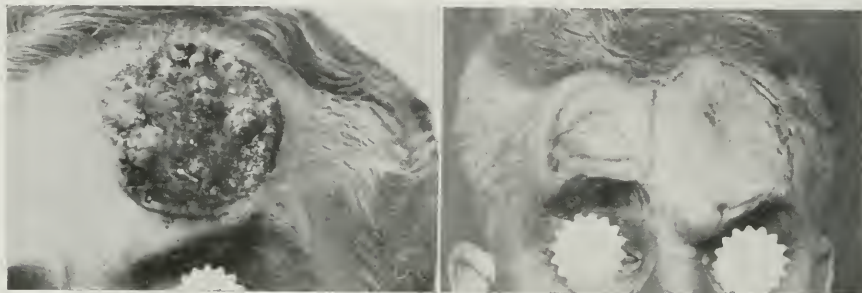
EPITHELIOMA OF THE FRONTAL REGION. IT HAD BEEN TREATED UNSUCCESSFULLY BY MANY METHODS, INVOLVING THE OUTER TABLE OF THE SKULL. DESTROYED BY ELECTRO-COAGULATION, TREATED BY DEEP ROENTGENOTHERAPY AND FOLLOWED BY A PLASTIC OPERATION.
